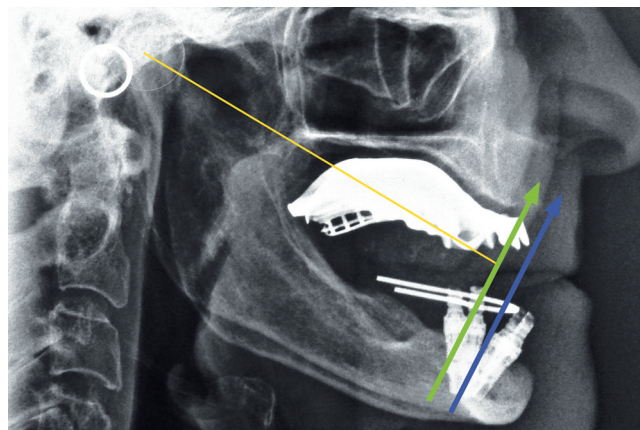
Lateral radiograph with implants and interim prosthesis. Loading axis (green arrow) and constraint axis (blue arrow) lie in same direction, perpendicular to closing radius according to tangent law. One to 2 mm of cortical bone left at anterior mandible lingual plate in apical area of anterior facially tilted implants.
